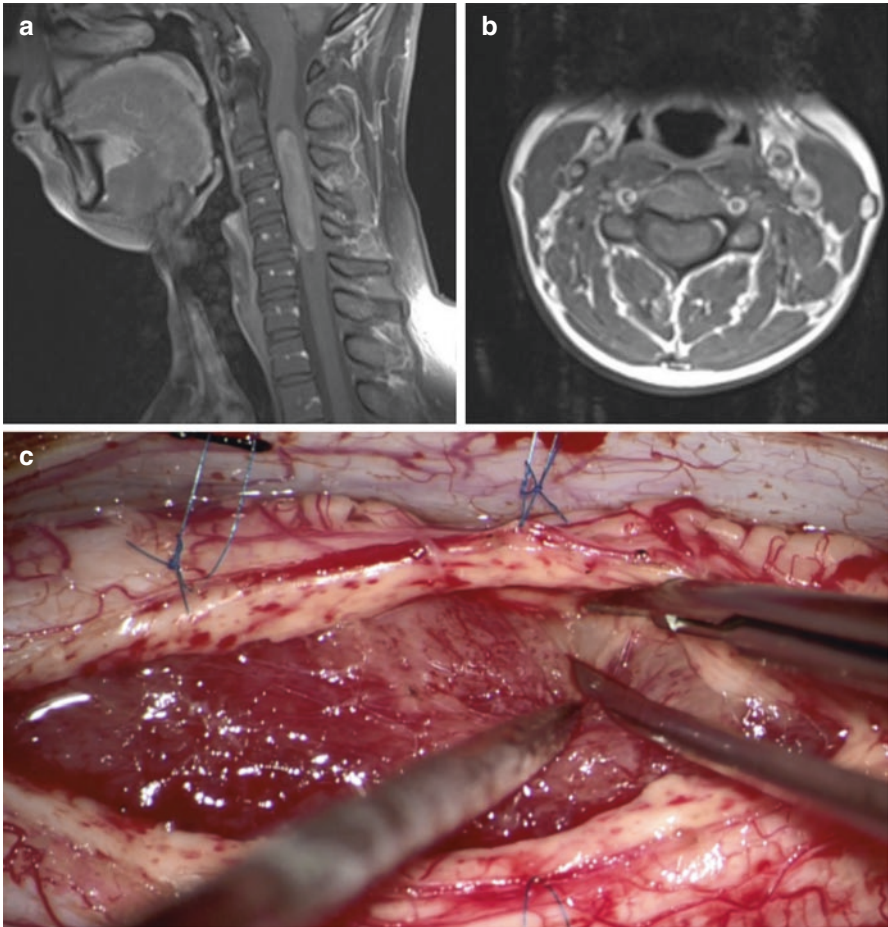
Cervical spinal cord ependymoma. (a, b) T1-weighted MRI images with gadolinium suggested a cervical spinal cord ependymoma. (c) A midline myelotomy was performed. The tumor had a clear interface separating it from the spinal cord providing for a gross total resection
